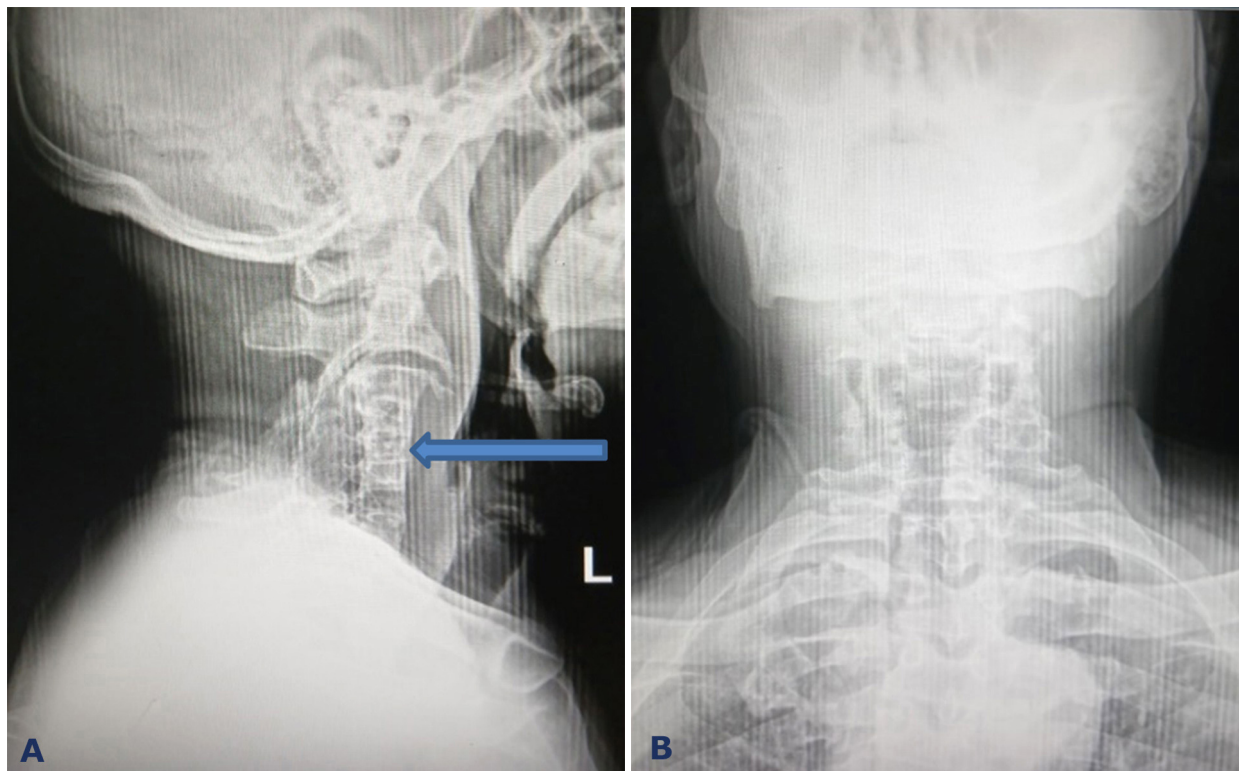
Cervical spine X-ray, lateral and antero-posterior views, showing a block cervical spine involving the entire subaxial cervical spine and the wasp-waist sign (blue arrow) as well as degenerative changes at the adjacent C2/3 level.
